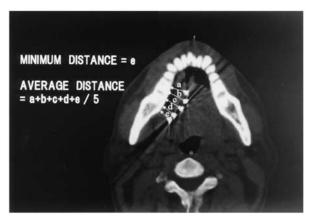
The method for computed tomography image tracing.
